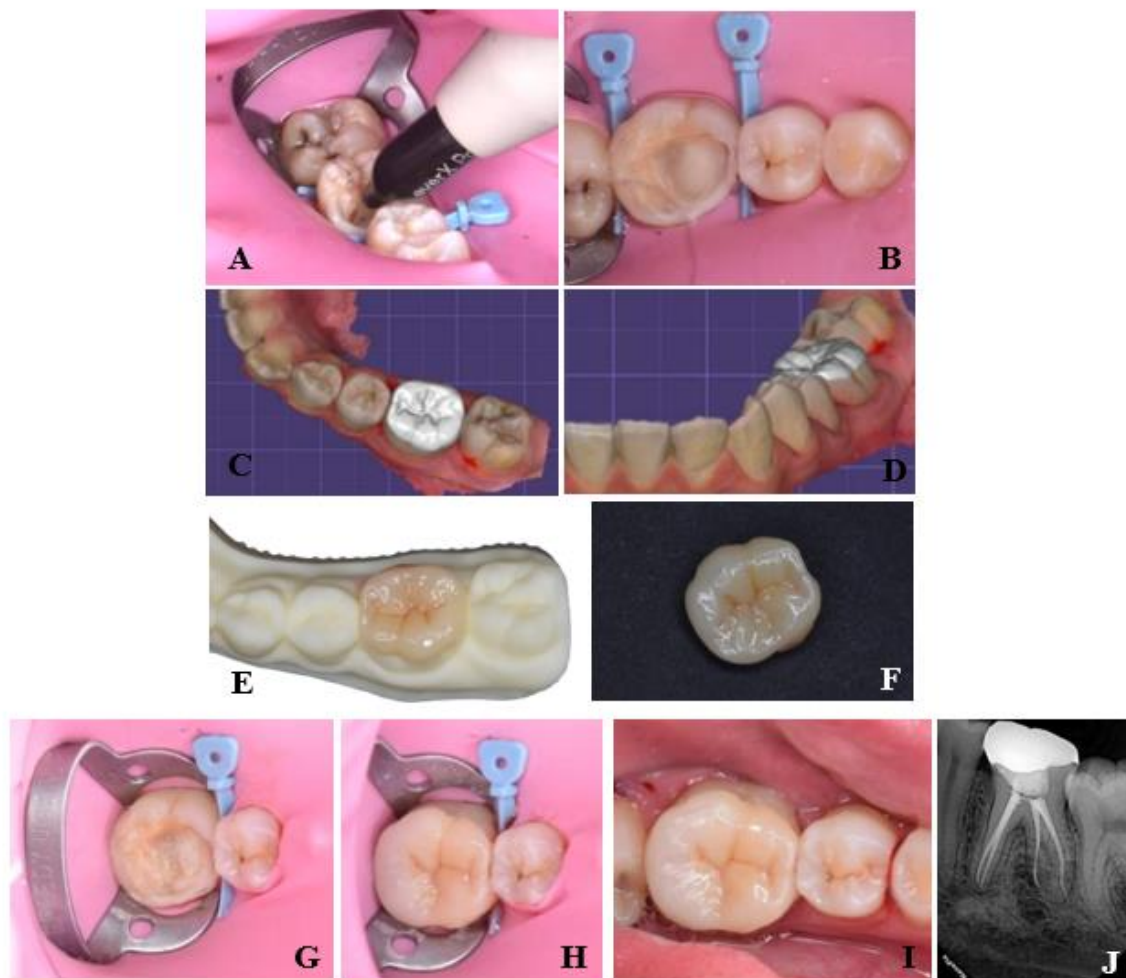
(A) EverX Posterior placement; (B) Onlay preparation; (C and D) Onlay design using CAD software; (E and F) Onlay Zirconia; (G) Tooth preparation for cementation; (H) Onlay cementation; (I) Clinical view after cementation; (J) Radiographic view after final restoration placement.
